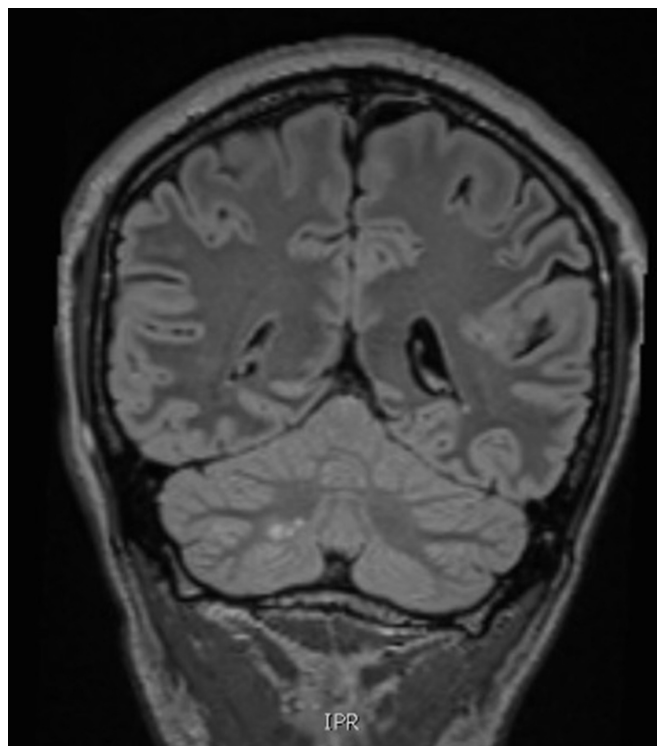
Coronal image of MRI brain showing cluster of infarcts in the inferior cerebellar peduncle, supplied by the right posterior inferior cerebellar artery.
